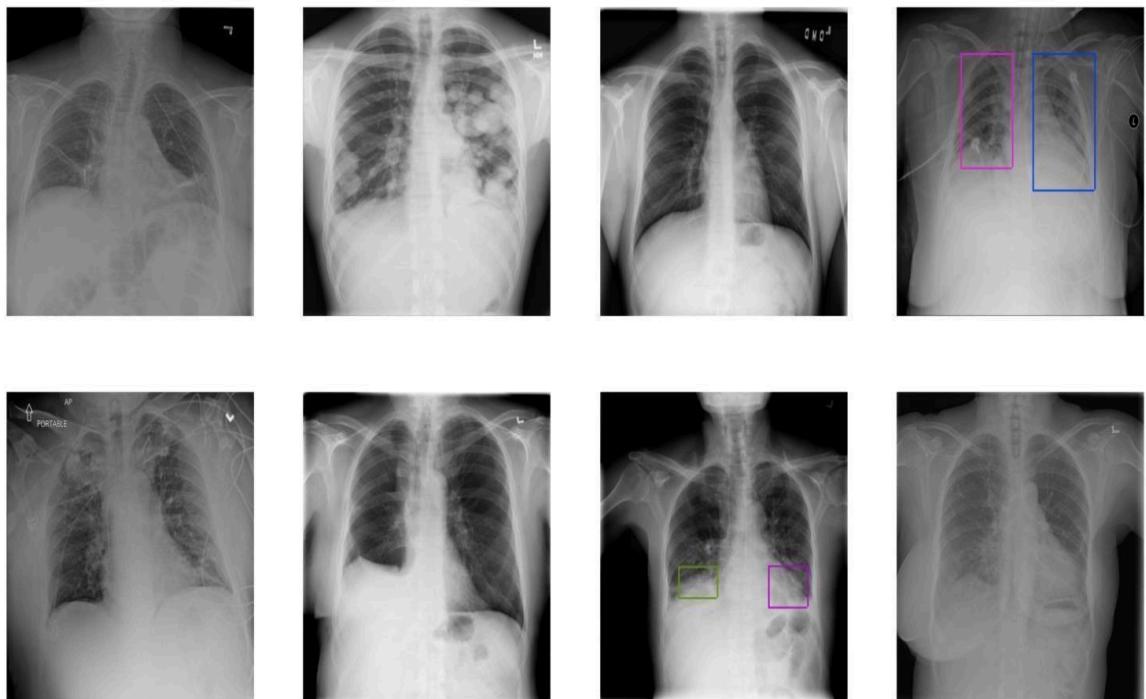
Sample visuals of chest X-Ray images along with Bounding Boxes
